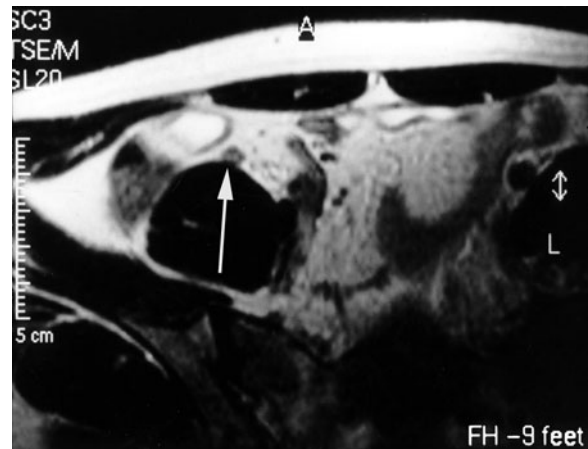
Axial T2-weighted image showing the normal appendix (arrow) coursing on the psoas muscle. The diameter is lower than 6 mm. No inflammatory changes in the surrounding tissue
